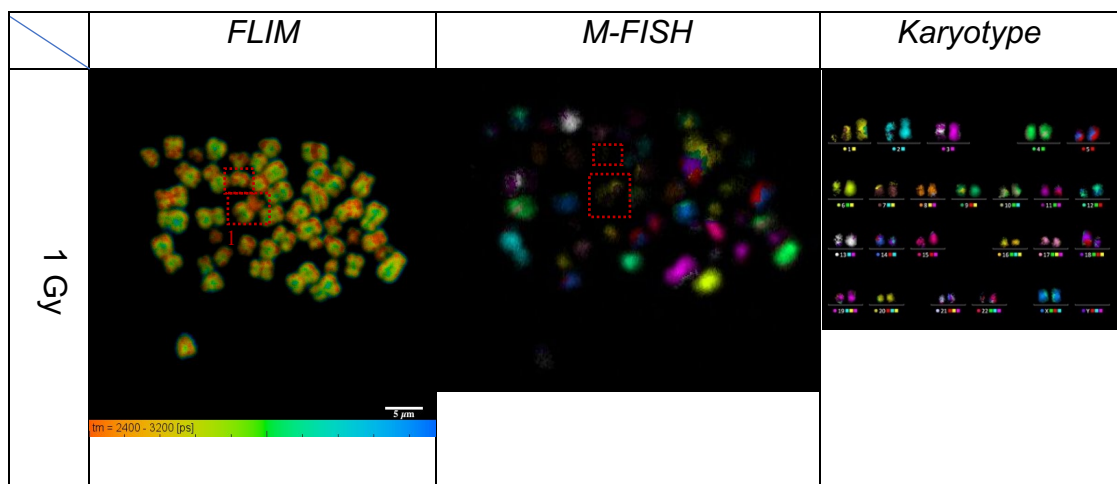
A spread irradiated at 1 Gy X-ray exposure. The red dotted box represents non-heterochromatin break of chromosome 1 and its fragmented pieces, shown in both FLIM and M-FISH image. Scale bar= 5 μ m.
